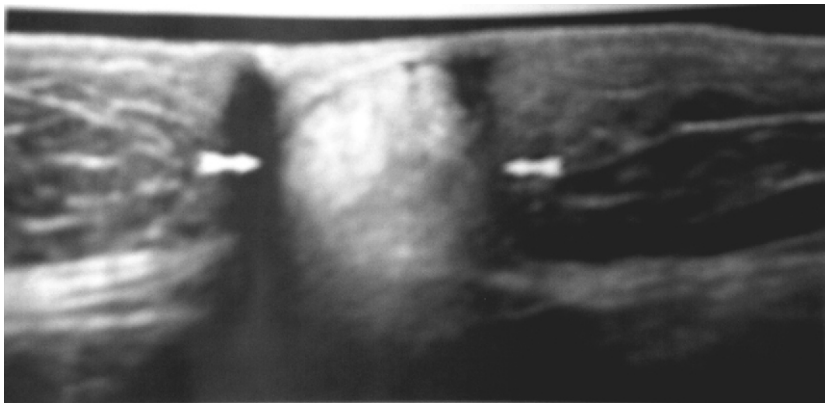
A Sonographical depiction of abdominal hernia with the herniated bowel loop and its gas content arrowed¹³. Unfortunately the sonographic picture for this case report is not available because it was mistakenly deleted from the archive or records when a repair service was carried out on the USS machine, before this report.
